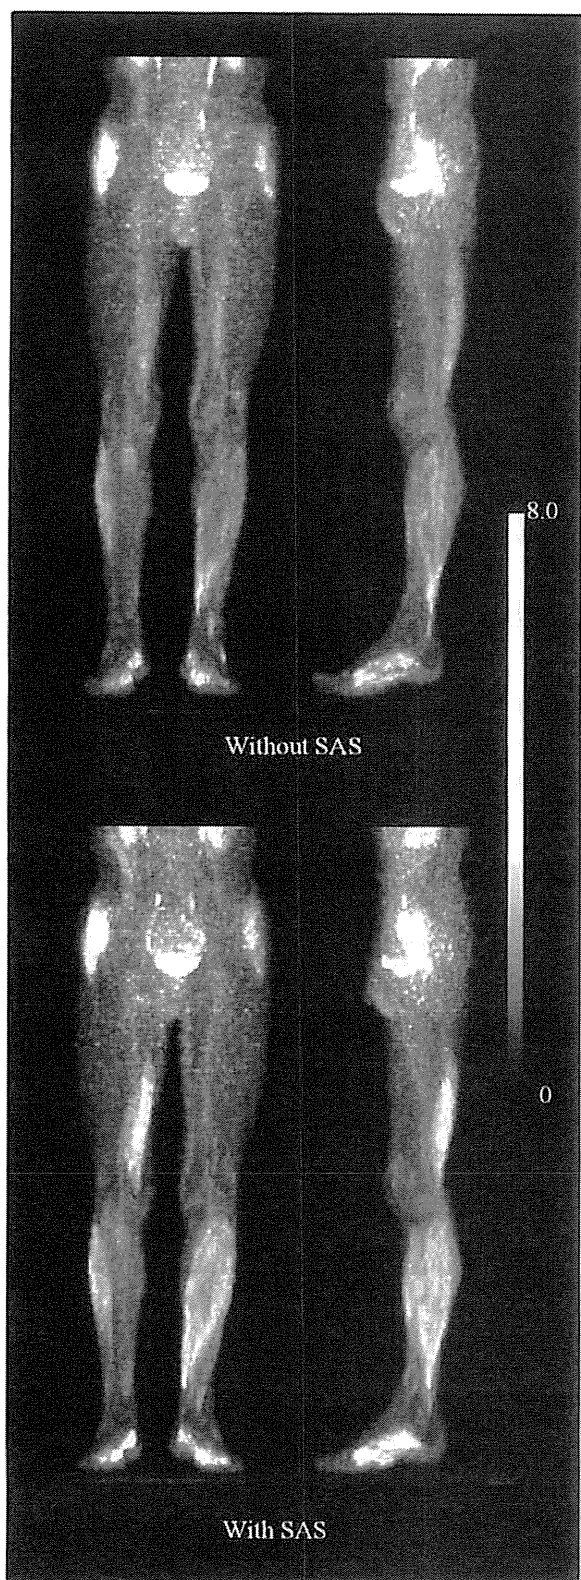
FDG PET images taken after walking without or with the SAS.
